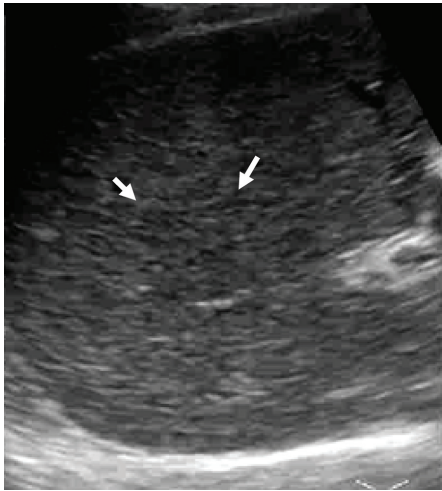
Isoechoic nodule: a nodule isoechoic to adjacent liver parenchyma an isoechoic nodule at right lobe liver, CT (not shown) confirmed the presence of HCC.
